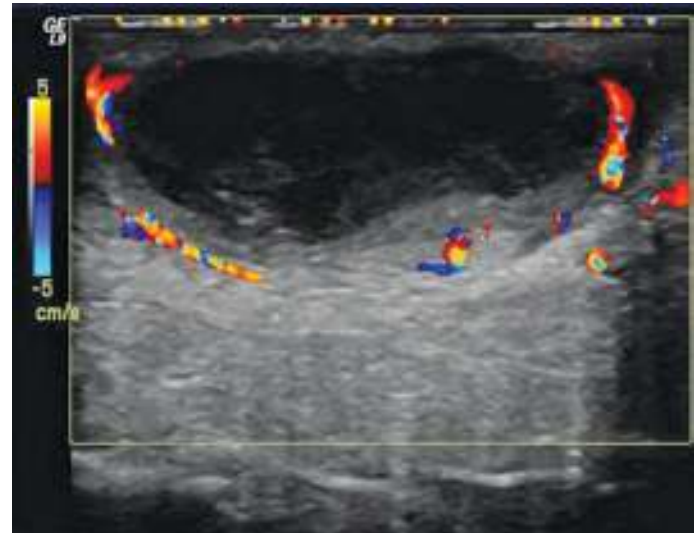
Color Doppler ultrasound image showing peripheral hyperemia around a large abscess cavity.
